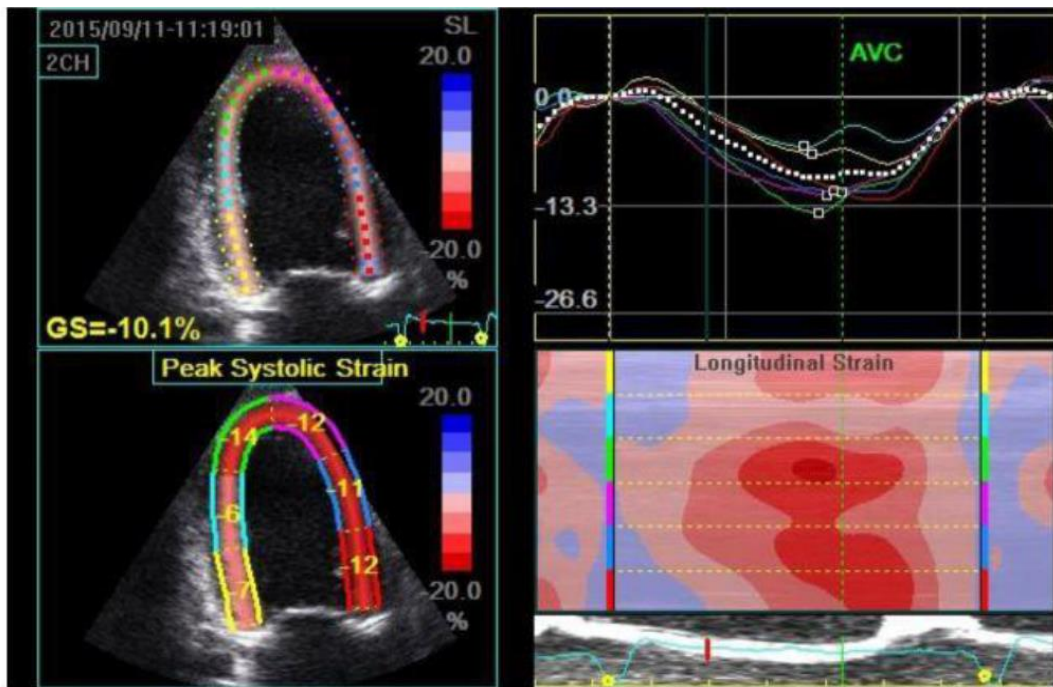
Quad display of apical two chamber view (A2C) showing different ways to depict global longitudinal strain (GLS) of LV.
